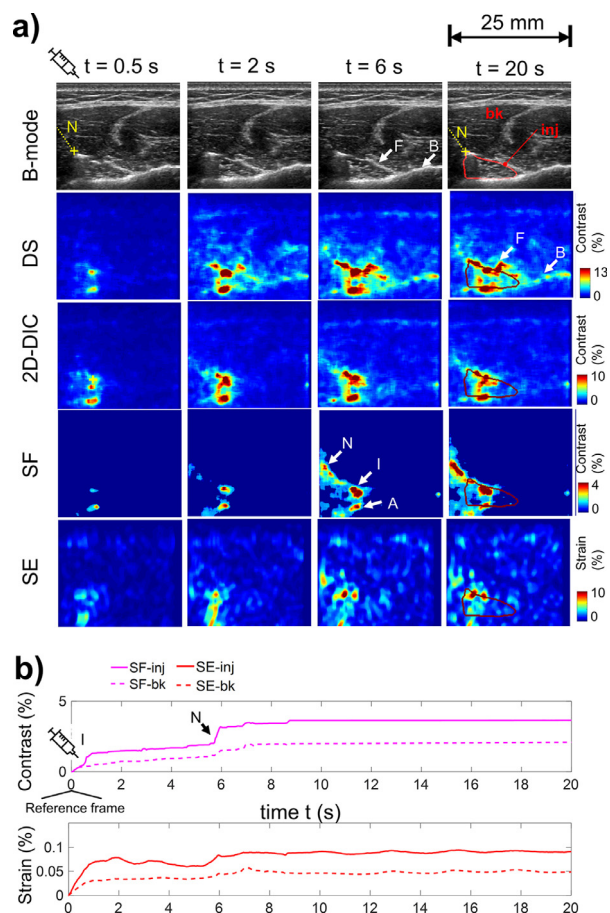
Exemplary *in vivo* ultrasound-guided BTX-A injection without contrast agent for a patient diagnosed with idiopathic mastocytary myalgia (IMM). (a) Selected injectate snapshots. The color bars are adjusted to the maximum observed variations. (b) Time profiles of echogenicity contrast and strain. Injection started at $t = 0.5$ s, with needle N marked in B-mode. At $t = 20$ s, cine annotation of injectate spread (inj) is plotted as a red contour. Injectate (I) is successfully delineated by the US quantification algorithms, with additional artifacts caused by tissue movement (needle N, fascia F, bone B) and acoustic shadows (A). The 2-D Digital Image Correlation (2-D-DIC), Strain Elastography (SE), and Spatiotemporal Filtering (SF) algorithms reduce bone and fascia artifacts in Direct Subtraction (DS). Acoustic shadows are alleviated by both SE and SF. Needle ejection at 6 s leads to a coherent contrast change, which is captured by SF. Otherwise, SF achieves almost total noise cancellation in the background (bk) region outside of the injectate.
